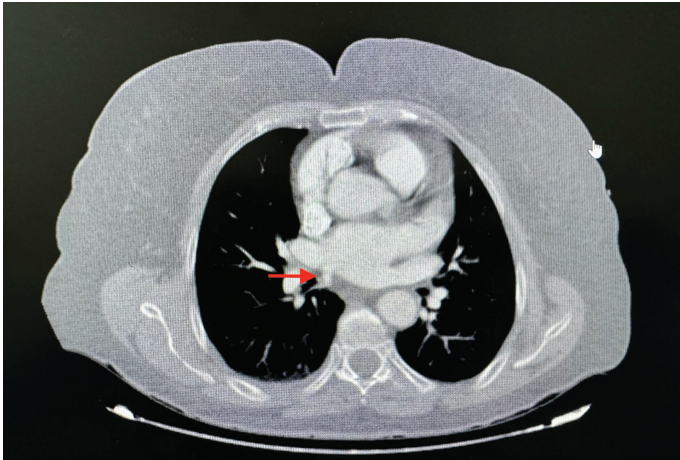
Contrast-enhanced computed tomography angiography image.
